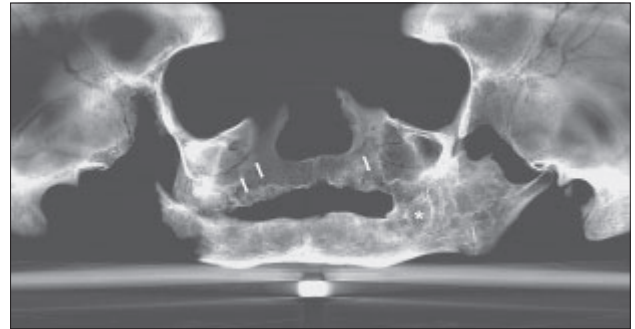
Orthopantomographic view of this skull; thick arrows – cavities inside alveolar crest; thin arrow – compact bone surrounds mandibular canal (iCATvision).
